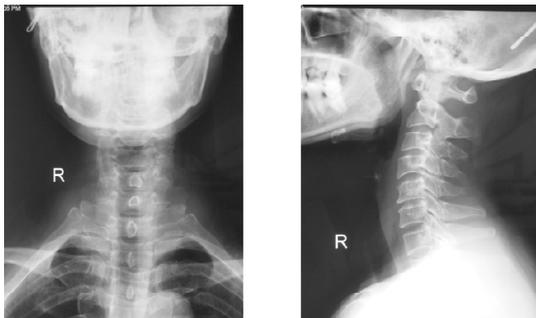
Preoperative anteroposterior x-ray showed narrowing of C3/4 intervertebral space
